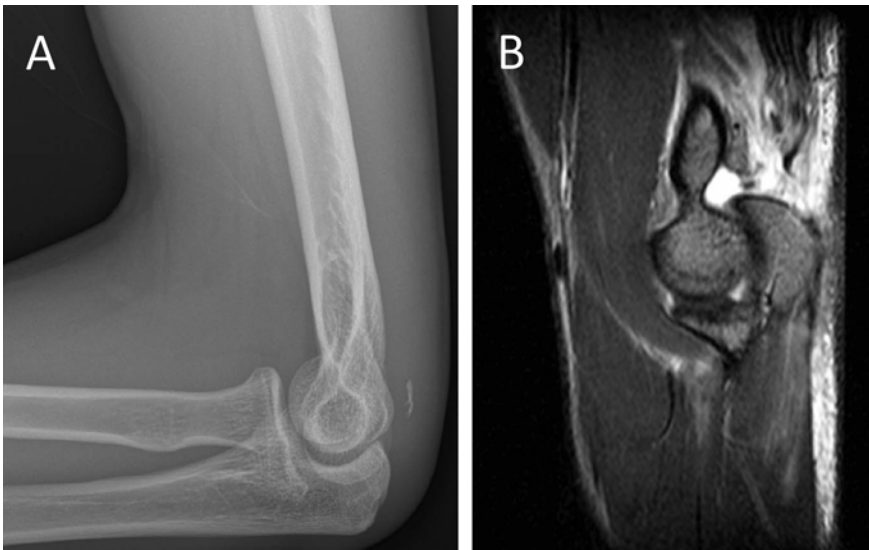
Imaging of left elbow. (A) Radiograph of the lateral elbow showing a flake of bone avulsed from the olecranon indicating a triceps tendon tear. (B) STIR MRI of the left elbow showing a fluid gap between the olecranon and distal triceps tendon consistent with a triceps tendon tear.
